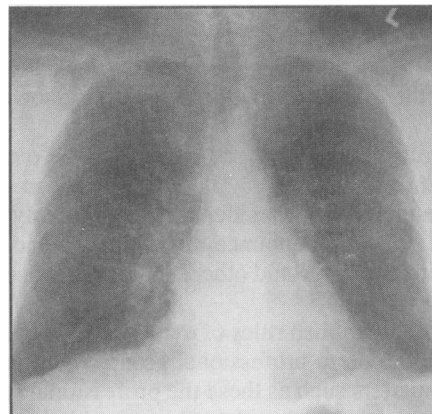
Chest radiograph on admission with pulmonary edema.
